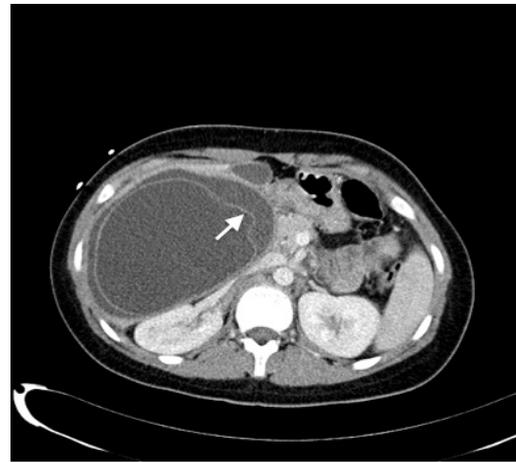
The abdominal computed tomography with intravenous contrast scan revealed a cystic lesion in liver segments V and VI (148X 100 mm) with a curvilinear linear image inside it (arrow) that corresponds with the endocyst detachment.
